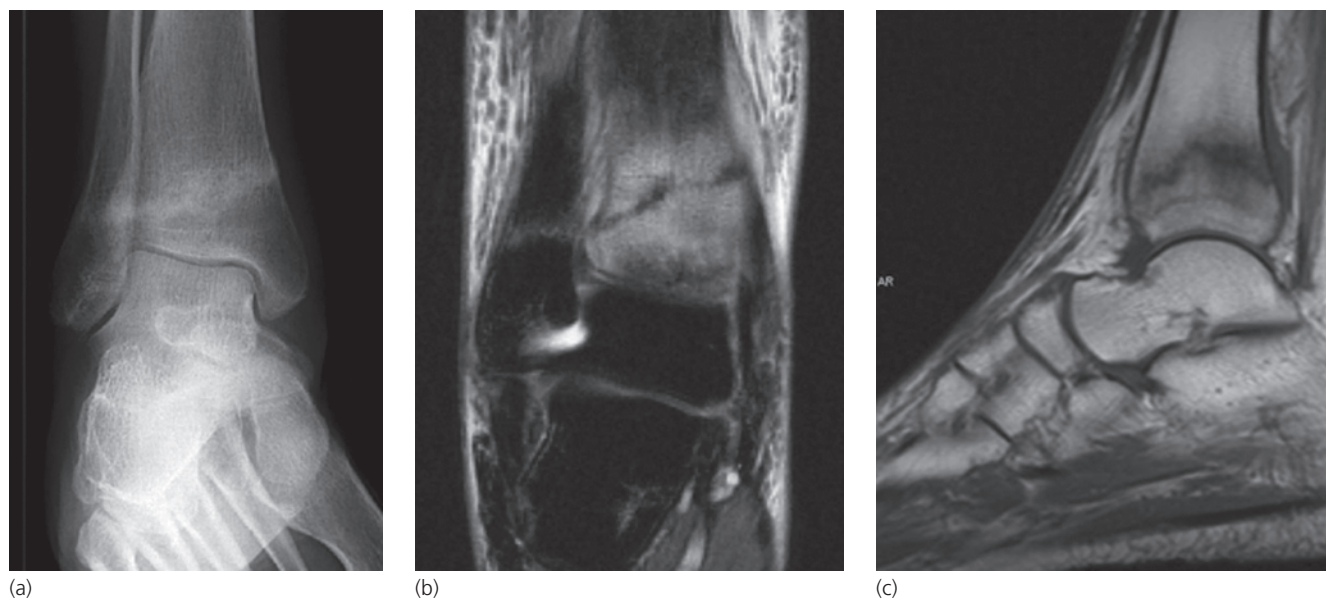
Tibial and fibular stress fractures. (a) Oblique ankle radiograph shows linear, oblique sclerotic lines in the distal tibia and fibula. (b) Coronal fat-suppressed proton density image shows the low signal fractures in the distal tibia and fibula with adjacent marrow edema, more marked in the tibia. (c) Sagittal T1-weighted image shows the low signal intensity tibial fracture line. T1-weighted images are best at depicting the fracture line.
